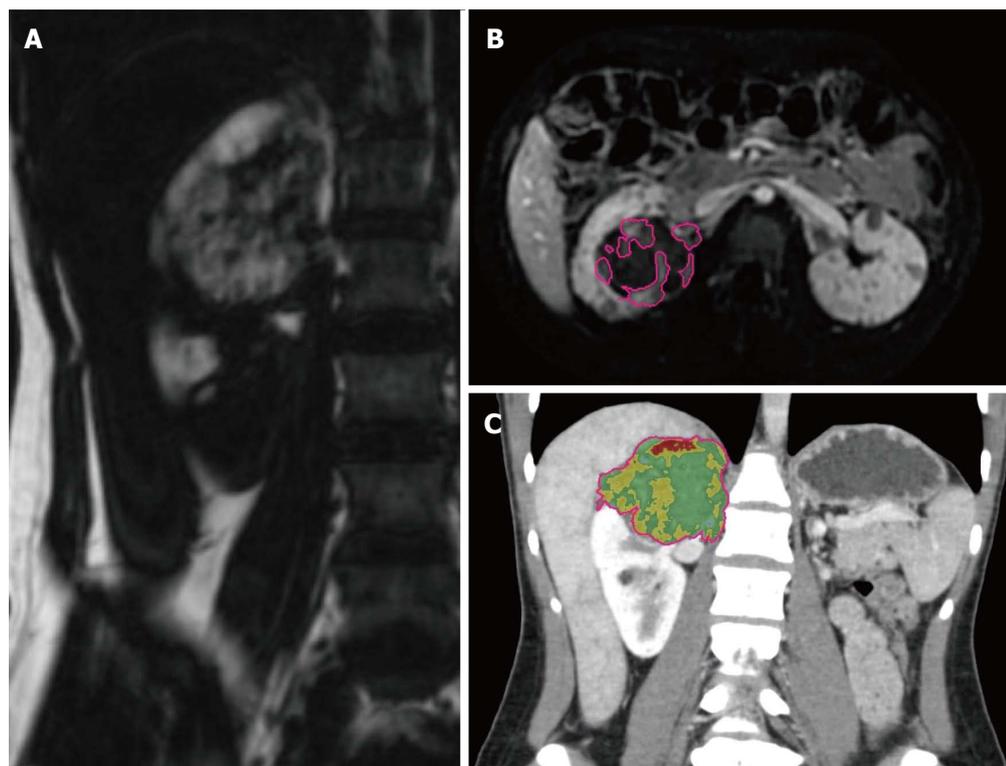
Examples of volumetric analysis on computed tomography and magnetic resonance imaging. A: Coronal "fat-only" maps created from in- and opposed-phase gradient recalled imaging were used to measure macroscopic fat volumes within AMLs; B: Segmentation of tumoral vascularity (automatically generated regions of interest demarcated by pink line) from post-contrast subtraction imaging was used to calculate tumor vascular volumes; C: Histogram analysis from CT was used to calculate tumoral fat and vascular content (pseudocoloring depicts fatty tissue as red and vascular tissue as yellow). CT: Computed tomography; AML: Angiomyolipoma.
